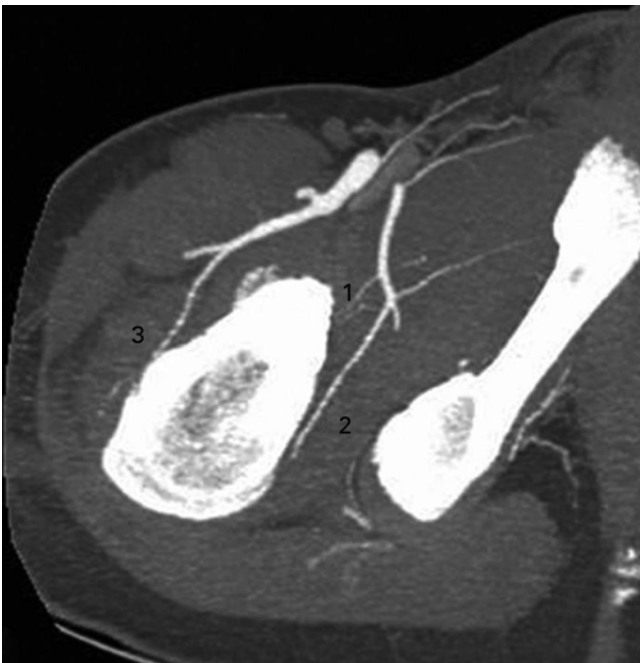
Maximum intensity projection image of the angio-CT scans showing the posterior inferior nutrient artery (1), the deep branch of the medial femoral circumflex artery (2), and the anterior nutrient artery of the femoral neck (3) (Reproduced with permission and copyright © of the *British Editorial Society of Bone and Joint Surgery* [14])
